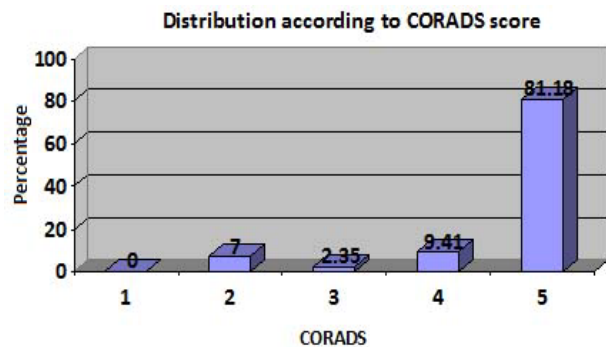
Distribution of patients according to CT CO-RADS score
